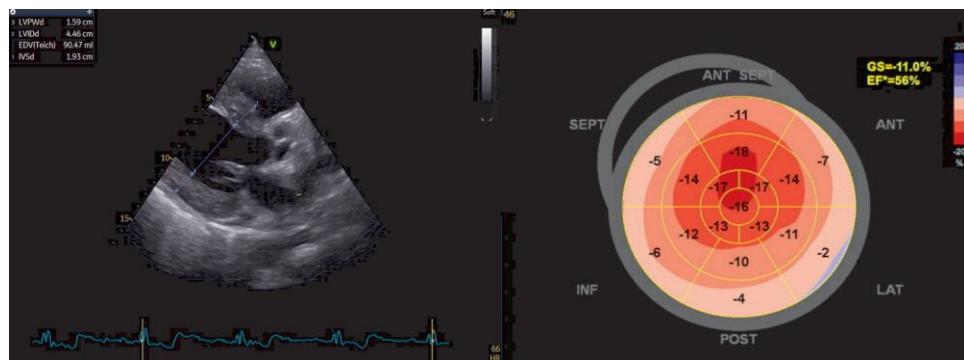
Transthoracic echocardiography demonstrating marked concentric left ventricular hypertrophy (interventricular septum, 19.3 mm; left ventricular end-diastolic diameter, 44.6 mm; posterior wall thickness, 15.9 mm) and reduced global longitudinal strain with apical sparing, findings highly suggestive of cardiac amyloidosis.
